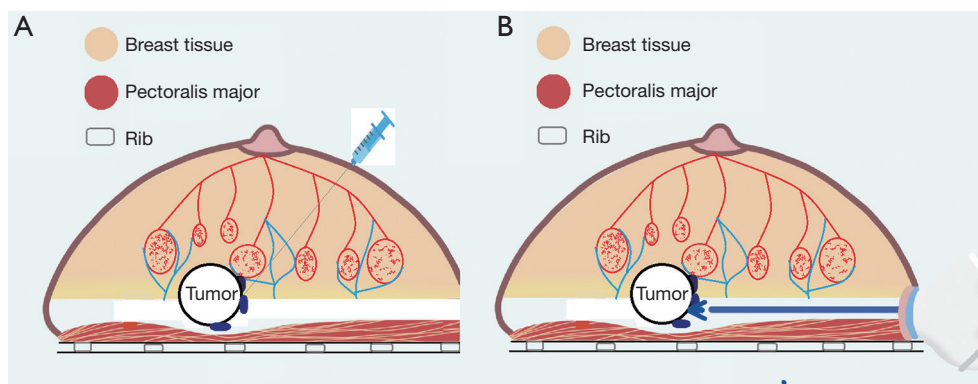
Multi-point injection of methylene blue was performed under ultrasound guidance before the operation, the needle was passed through the entire layer of the gland to reach the posterior space of the mammary gland, avoid passing through the tumor. The methylene blue injection sites were visible under the surgical field, and the surgery was performed under methylene blue guidance. (A) MBL sketch map; (B) endoscope resection guided by MBL (the blue arrow represents the top of the electric hook). MBL, methylene blue location.
